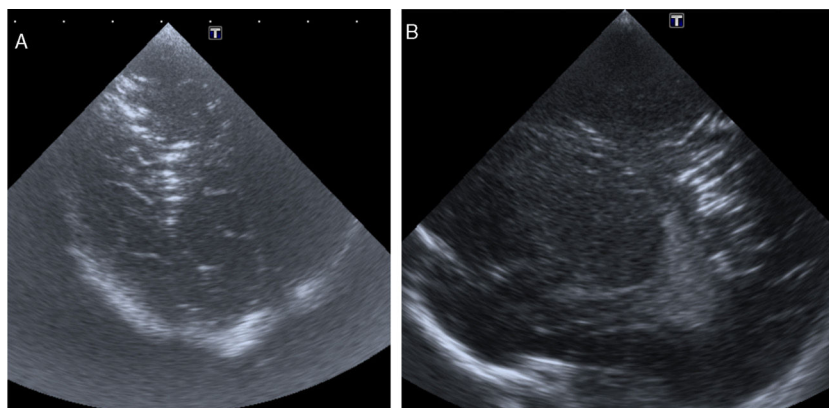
Cranial ultrasound angled coronal (A) and right sagittal (B) views showing parallel hyperechoic bands forming a semi-oval outline in the deep white matter of the right hemisphere. Features compatible with cerebral air embolism.
